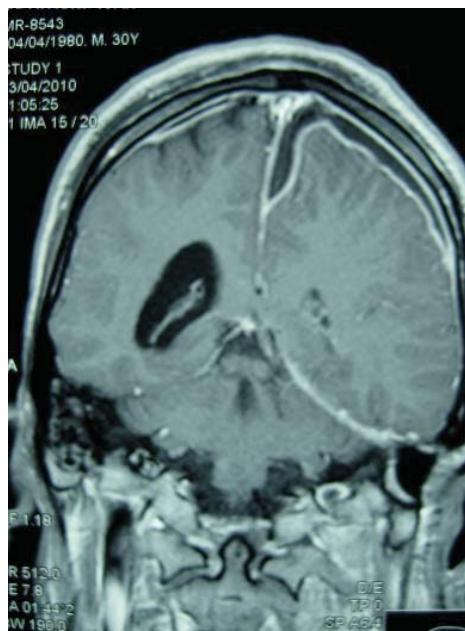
Magnetic resonance imaging (MRI) interpreted as subdural collections of thick fluid, in the frontoparietal region and also next to the cerebral falx in the parietal region (T1W coronal cross-section and postcontrast)
